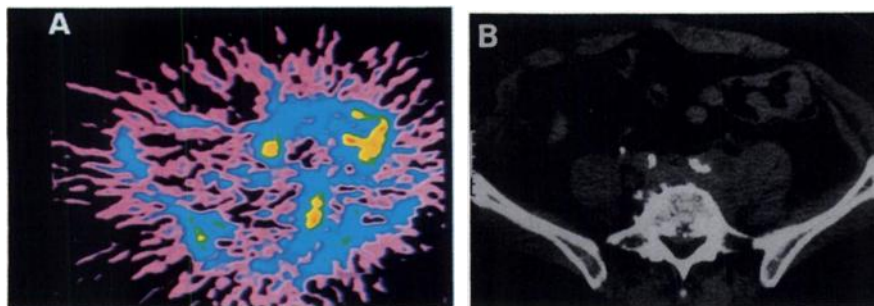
(A) PET image of Patient 6. Carbon-11-methionine accumulation is clearly seen in the large partially necrotic tumor in the abdomen consisting of immunoblastic lymphoma (high-grade). The necrotic part of the tumor does not accumulate methionine. The image is summed up over 15–40 min postinjection. The injected dose of ^{11}C -methionine was 260 MBq. Total counts of the image was 7×10^5 . (B) CT scan from the same plane.
